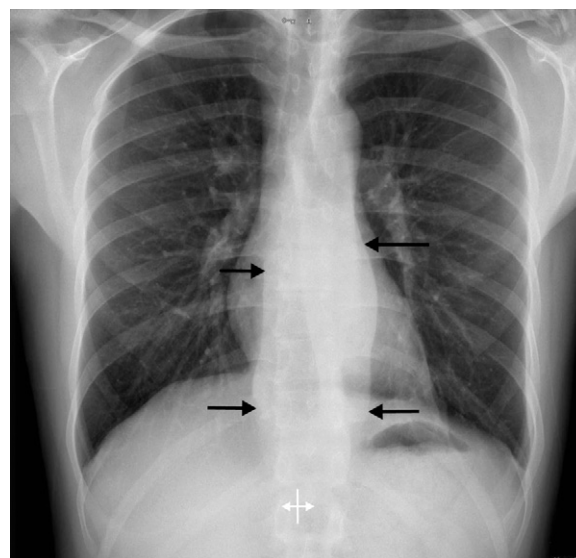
Chest X-ray imagination showing the borders of abscess which mimicks aortic aneurysm.
